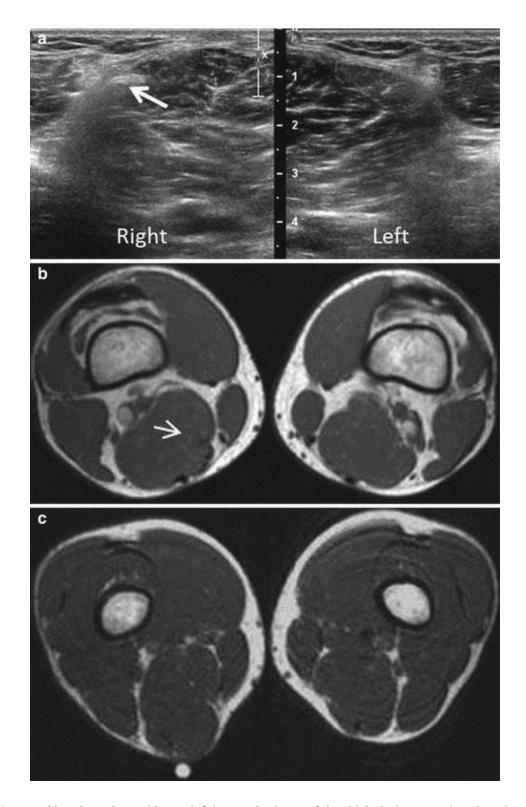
A 16-year-old male patient with a painful posterior lump of the thigh during exercise, thought to be a muscular herniation. Transverse ultrasound image (a) of the thigh rules out herniation and shows a bipennate appearance of the muscle around an internal tendon (arrow), compared to the contralateral side. Axial T1-weighted MRI (b) confirms the findings of the ultrasound. Additional axial T1-weighted MRI (c) during contraction of the thigh confirms that congenital bipennate organization of the muscle explains non symmetrical contraction of the muscle in this young adult
